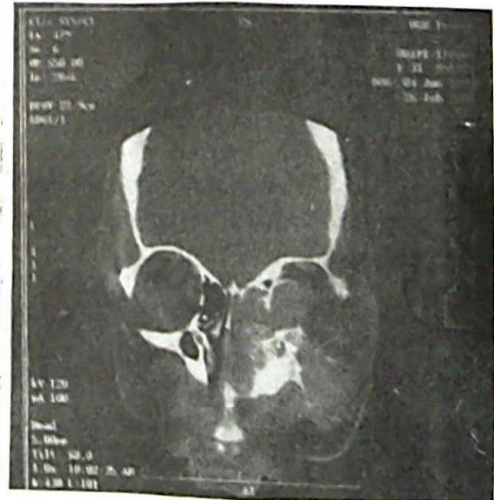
CT scan of the sinuses and brain (coronal view)
